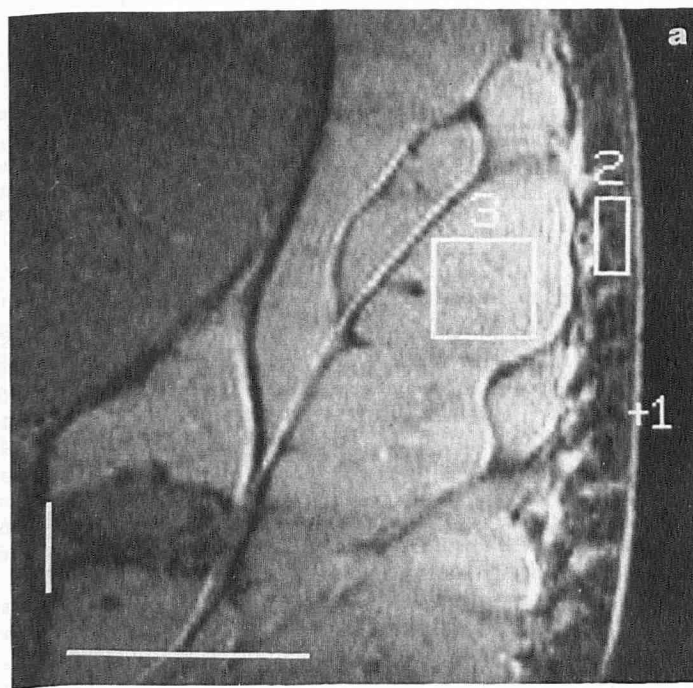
Skin on calf. *a*, magnetic resonance image of skin in vivo on calf. Layers of skin are clearly delineated: the outer bright thin layer corresponds to epidermis, measuring about 100 μm in thickness. Cursor 1 represents one of the 40 pixels selected in epidermis. Dermis (region 2) appears as a dark layer about 1 mm thick. It is quite inhomogeneous because of grey inclusions that are pilosebaceous units. Hypodermis (region 3) appears bright and its darker fibrous septae are clearly visible. Regions 2 and 3 represent some of the five ROI selected in each layer for relaxation time calculations. Bars, 5 mm. *b*, plots of typical experimental points and the resulting fitted curves from one of the five ROI for dermis and hypodermis and from averaged 40 pixels in epidermis. Data values for T1 calculation are obtained with a spin-echo sequence for seven values of TR. *c*, plots of typical experimental points and the fitted curves from a ROI (or averaged 40 pixels in epidermis) obtained for T2 calculation with a gradient-echo sequence and five values of TE. In hypodermis, data values are obtained with a spin-echo sequence and eight values of TE (see text). Error bars around the data points, standard deviation between pixels of the selected ROI.
